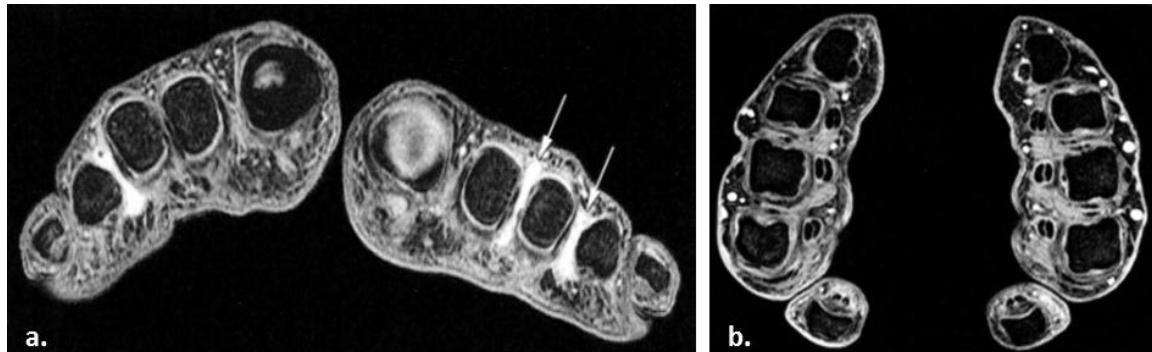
MRI appearance of forefoot bursae in patients with RA
